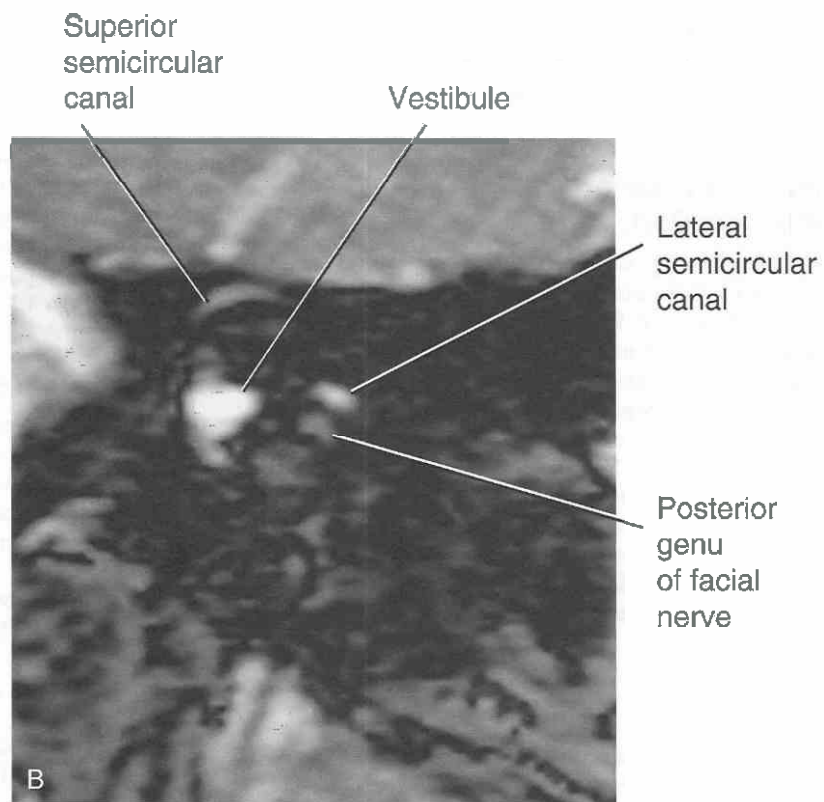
Coronal views, normal anatomy. *A*, Posterior coronal CT section of the temporal bone centered at the level of the round window and the tympanic sinus. The air spaces extend all the way to the otic capsule membrane surfaces. The adjacent posterior genu of the facial nerve and vestibule are seen. Other depicted structures include the posterior internal auditory canal, superior semicircular canal, lateral semicircular canal, styloid process, and external auditory canal. *B*, Coronal MR section.
